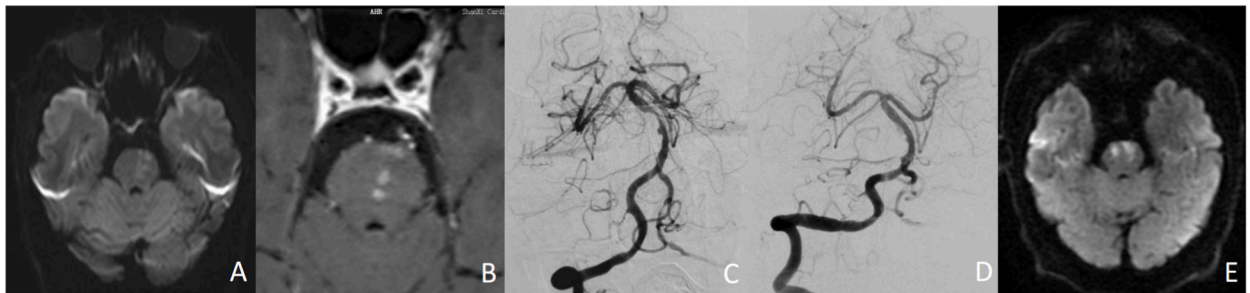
A typical case of acute cerebral infarction is severe stenosis of the middle basilar artery. Male, 64 years old, main reason: “dizziness with right limb weakness for 5 days” admission, history: diabetes, smoking, alcohol history, diagnosis of acute cerebral infarction, severe stenosis of the middle basilar artery. Preoperative physical examination: clear consciousness, fluent speech, limb muscle strength level 5, NIHSS score 0, mRS score 0 points; Preoperative DWI (Fig. A) shows: acute stage of left cerebral infarction of pontine hematosis; The preoperative axial position HRMR—VWI (Fig. B) showed that the basilar artery plaque was eccentric, and the surface was punctate and significantly strengthened, and the plaque mainly affected the dorsal and right sides of the basilar artery wall. Preoperative digital silhouette angiography (Fig. C) showed severe stenosis in the middle of the basilar artery; Endovascular treatment showed significant improvement in stenosis with a balloon dilation at basilar artery stenosis and implantation of one Enterprise2 4.0 × 23 mm stent (Fig. D). 24 h postoperative review DWI showed that the acute stage of bilateral cerebral infarction of the pontine (as shown in Figure E), 7 d postoperative physical examination: clear consciousness, unable to speak, right limb muscle strength level 0, left upper limb muscle strength level 4, left lower limb muscle strength grade 2, NIHSS score 16 points, mRS score 4 points.
